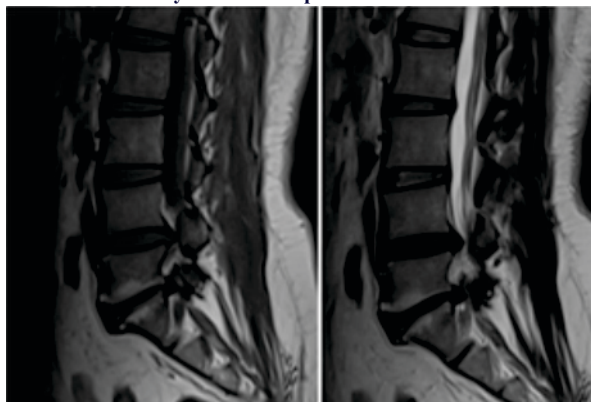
MRI T1 and T2 weighted sagittal images showing type II Modic changes (hyperintense on both T1 and T2) in L5-S1 end plates in 50 year old female patient.
